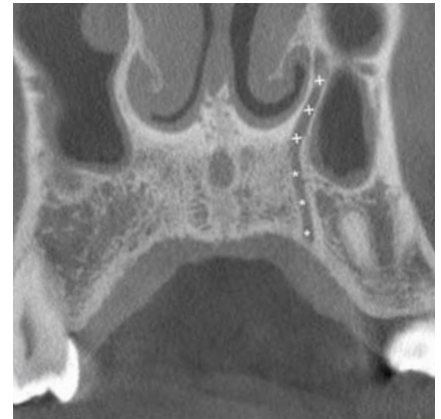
Coronal CBCT slice
